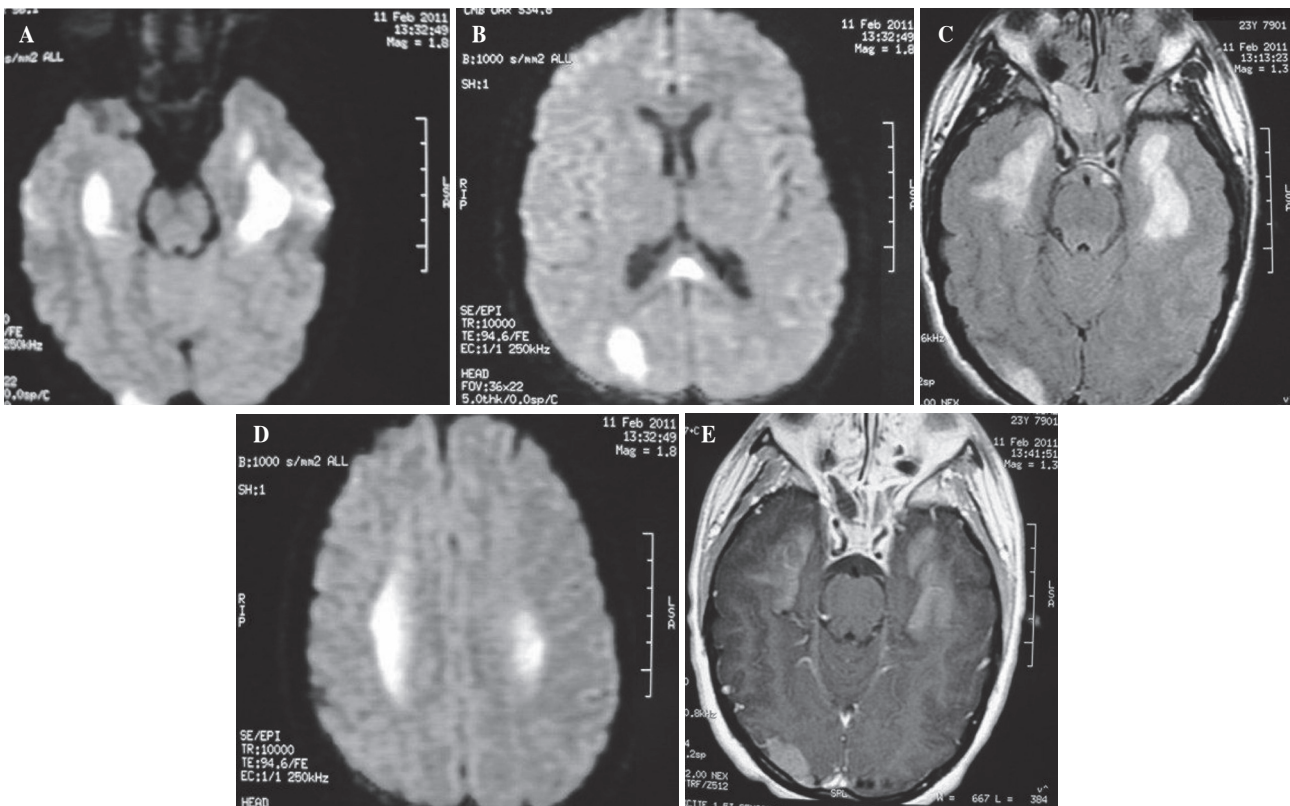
23 year old female who had inhaled heroin 1 week before. (A) Axial T2-weighted MR image and (B) FLAIR image: hyperintensity in the temporal lobes and an area of hyperintensity in the right occipital lobe. (C) Axial DWI reveals restricted diffusion bilaterally in the temporal lobes and right occipital lobe, (D) in the right occipital lobe and splenium and in the centrum semiovale. (E) Contrast-enhanced axial T1W image demonstrates enhancement bilaterally in the temporal lobes and right occipital lobe.
